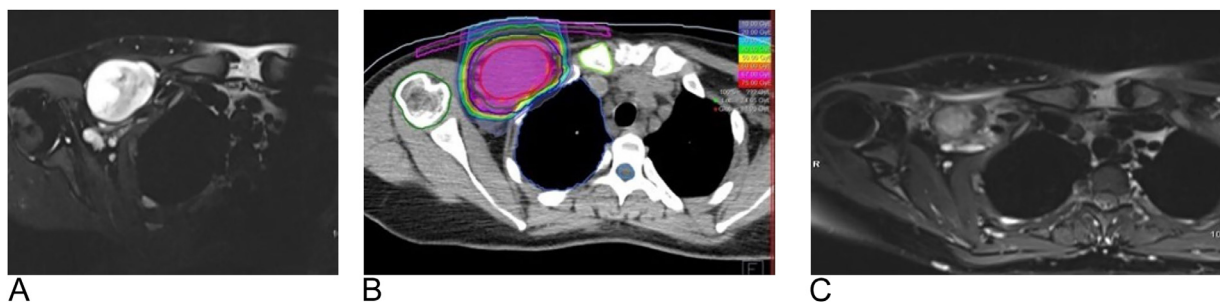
Representative plan with 1 dose level. MPNST treated with postoperative carbon ions RT. A 21-year-old female with low-grade MPNST NF1-associated, and of brachial plexus. The patient underwent postoperative CIRT for recurrence after surgery, with a total dose of 70.4 Gy (RBE) in 16 fractions. (A) Tumor volume pretreatment and (B) CIRT. (C) MRI after 16 months showed a partial response. Follow-up after 8 years still showed partial response in stable disease. The low-grade and complete high-dose coverage were associated with long-term local control.
